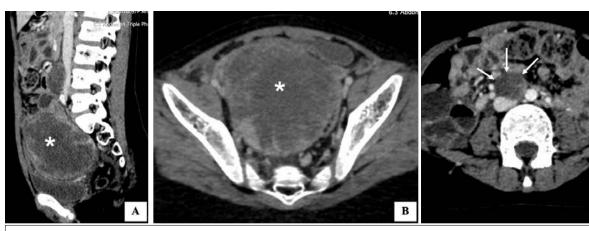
Sagittal reformatted (A) and axial (B and C) contrast enhanced CT images show a heterogeneous lesion in the pelvis (asterisk) with enhancing solid areas, predominantly in the periphery. An enlarged heterogeneously enhancing paraaortic lymph node is also noted (white arrows).
